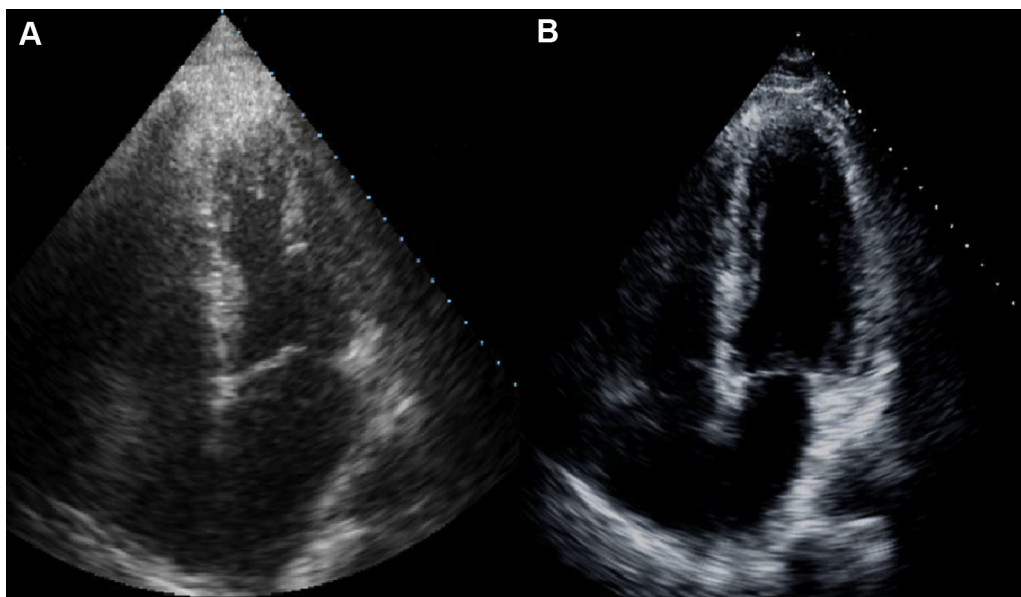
Transthoracic echocardiograms showing A: presenting left ventricular apical ballooning and B: resolution.
